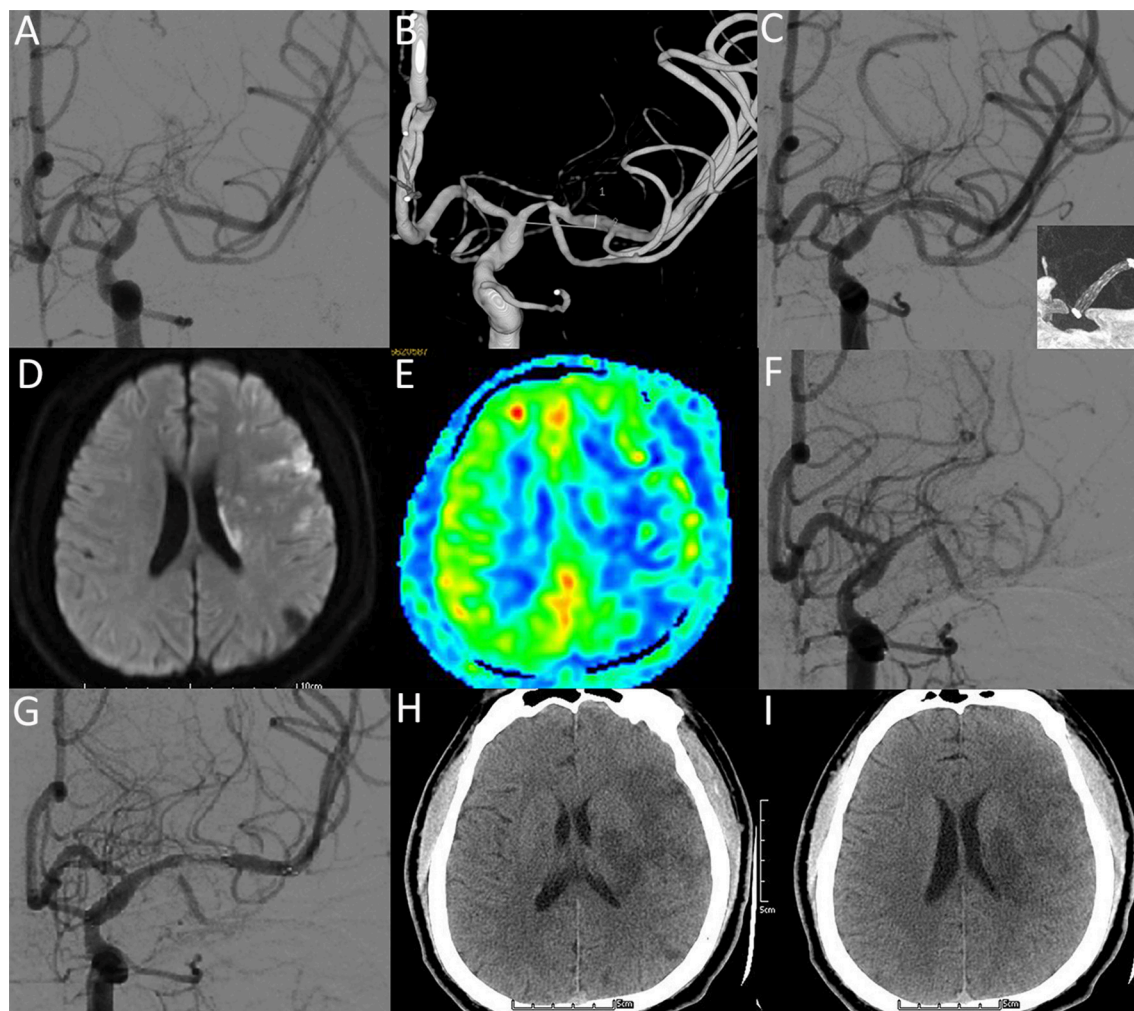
A 28-year-old male with a significant symptomatic stenosis of the left M1 segment. (A,B) Preprocedural DSA image demonstrates high-grade stenosis. (C) Postprocedural DSA image demonstrates a 20% residual stenosis (NIHSS: 0). Insert: VasoCT showing patent stent lumen with good stent vessel apposition. (D-F) Two days after stenting, DWI (D) and ASL (E) images reveal new infarctions and hypoperfusion in the territories of the left MCA (NIHSS: 14). DSA image (F) demonstrates complete occlusion of the left MCA. After the intra-arterial administration of IIb/IIIa inhibitor and solitary stent deployment, DSA image (G) demonstrates recanalized flow of MCA (NIHSS: 14). Five days after recanalization, CT images (H,I) reveal hypointense lesions within the territories of the left MCA (NIHSS: 10).
